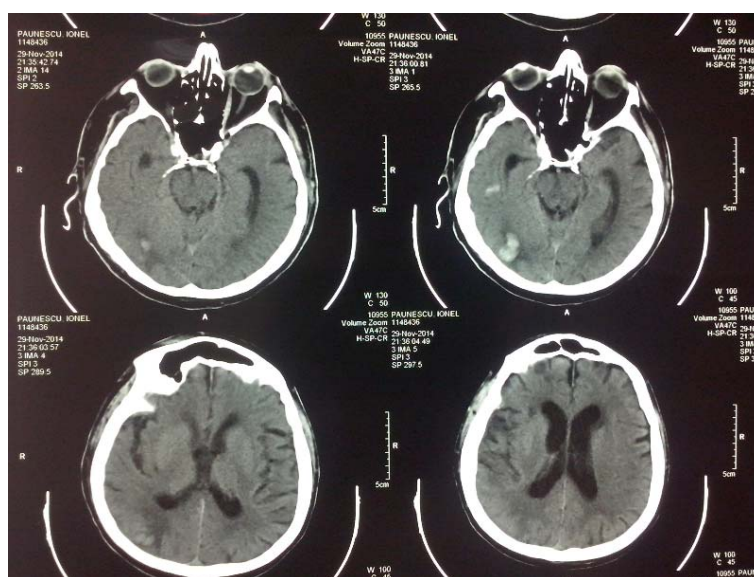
Cerebral CT scan-Right temporal and parieto-occipital intraparenchymatous hemorrhages, a right frontal sequela lesion, multiple old lacunar infarcts, cortical atrophy.
